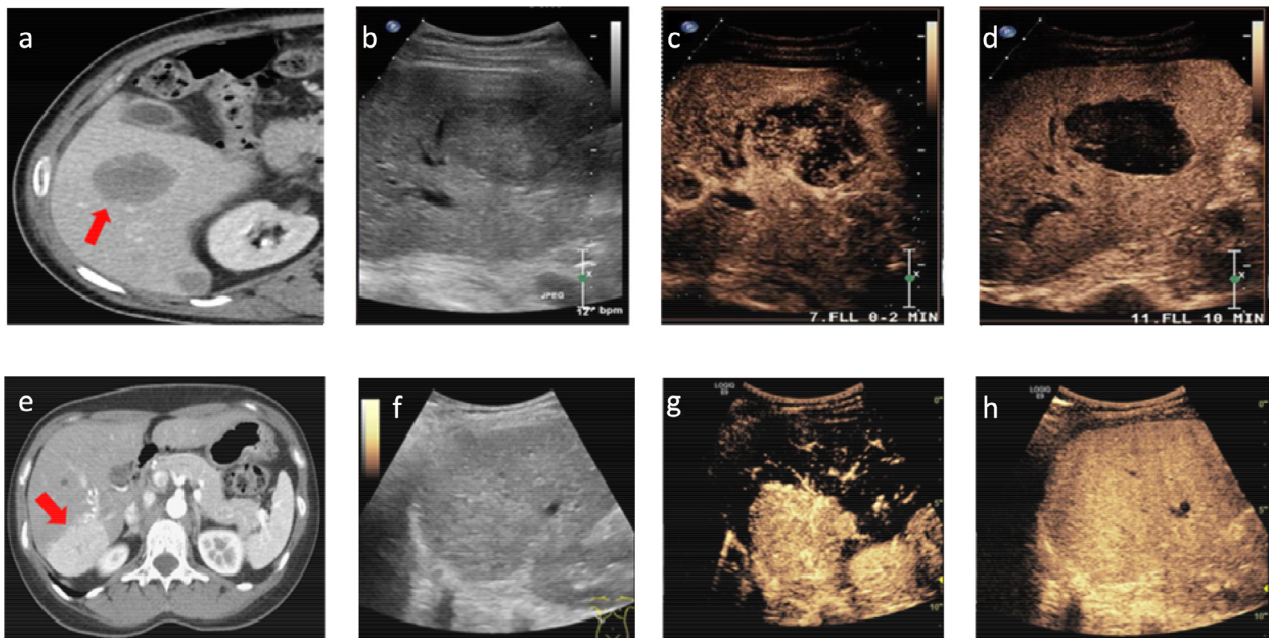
Sonozoid-enhanced imaging of focal liver lesions. (a–d) A 75-y-old man with liver metastasis; (e–h) A 38-y-old woman with FNH. (a) A CE-CT image displays slight peripheral enhancement with hypoattenuating centre. (b) Pre-contrast harmonic B-mode shows isoechoic metastasis. (c) Arterial phase post-Sonozoid injection shows metastasis with non-enhancing regions. (d) Kupffer phase at 10 min post-Sonozoid injection shows metastasis non-enhancing with well-defined rim. (e) FNH hyperintense representation in the venous/delayed phase on CE-CT. (f) Pre-contrast harmonic B-mode image of FNH. (g) Arterial phase shows well-defined lesion margins and central scarring. (h) Kupffer phase at 10 min post-Sonozoid injection shows homogeneous iso-enhancement of FNH. From: An Efficacy and Safety Study of Sonozoid and SonoVue in Participants With Focal Liver Lesions, Undergoing Pre- and Post-Contrast Ultrasound Imaging (ClinicalTrials.gov Identifier: NCT03335566). This phase 3 prospective study was conducted at 17 centres in greater China and Korea (May 2014 to April 2015). The study was approved by an independent ethics committee or independent review board at each clinical site according to national or local regulations. Written informed consent was obtained from all study participants. CE-CT = contrast-enhanced computed tomography; FNH = focal nodular hyperplasia.
